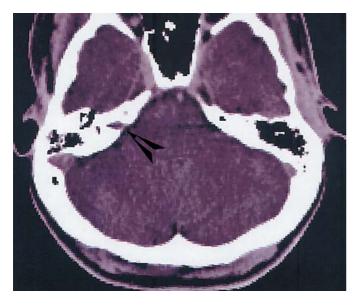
Axial CT with contrast demonstrating the right facial nerve neuroma (dark arrow) located in the cerebellopontine angle during treatment planning for FSRT.
